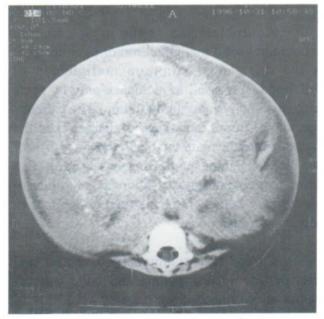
Contrast CT scan shows a huge inhomogeneous soft tissue mass with multiple stippled calcifications in the paravertebral region.
